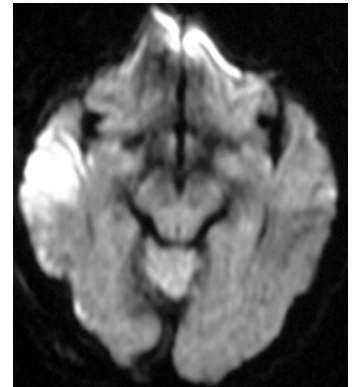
Diffusion-weighted MR image obtained 6 hours after the onset of headache and agitated delirium showing hyperintense lesions in the right temporal lobe.
